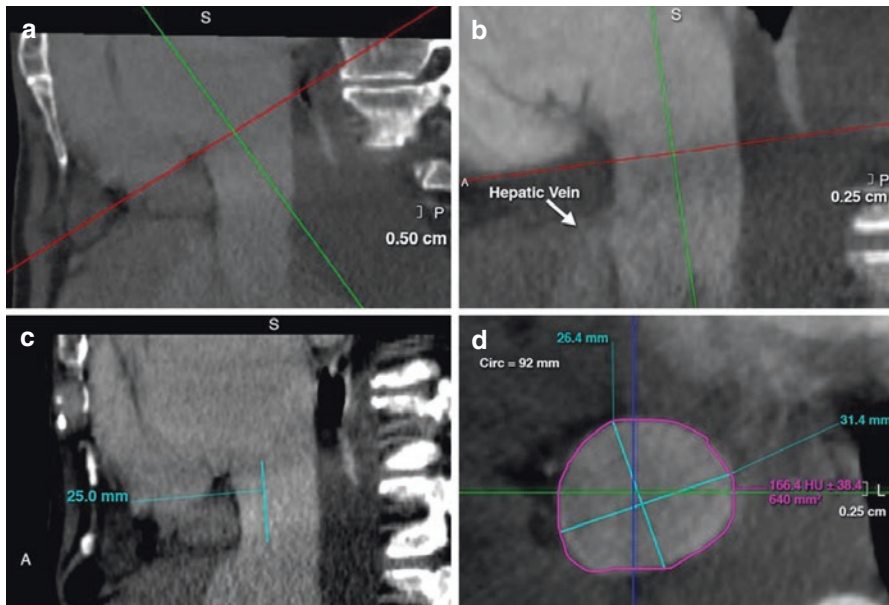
Computed Tomography for Caval Valve Implantation. (a) Assessment of the right atrium-inferior vena cava junction plane. (b, c) Depiction of the hepatic vein and (d) Sequential measurements of the horizontal planes for the assessment of the optimal valve size (1 cm below the right atrium-inferior vena cava junction plane and 1 cm above the identified first hepatic vein). Reprinted with permission from “Transcatheter Caval Valve Implantation Using Multimodality Imaging. Roles of TEE, CT, and 3D Printing,” by Brian O’Neill et al., JIMG 2015;8:221–225. Copyright (2015) by Elsevier Inc
